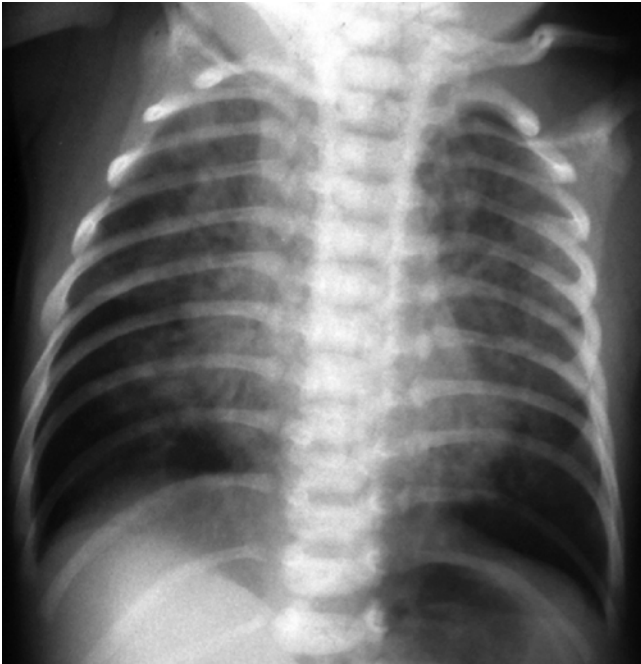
Chlamydia pneumonia. Radiograph of an afebrile 2-week-old girl with dry cough shows bilateral hyperaeration and diffuse interstitial infiltrates, appearing coalescent on the right
